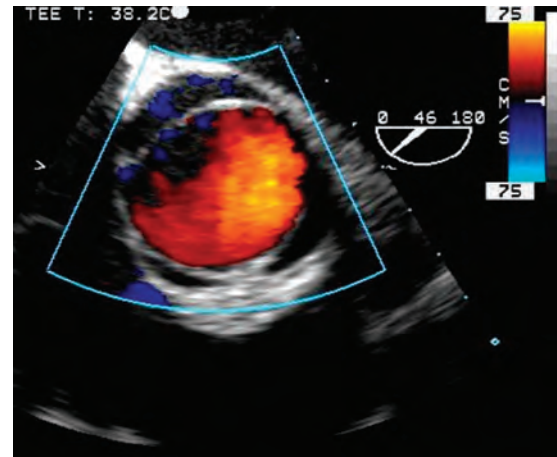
Midesophageal short-axis view of the aortic valve in systole (imaging angle of 46 degrees). Color-flow Doppler mapping shows laminar flow through the aortic valve consistent with an adequate valve area. There is no suggestion of aortic stenosis.
